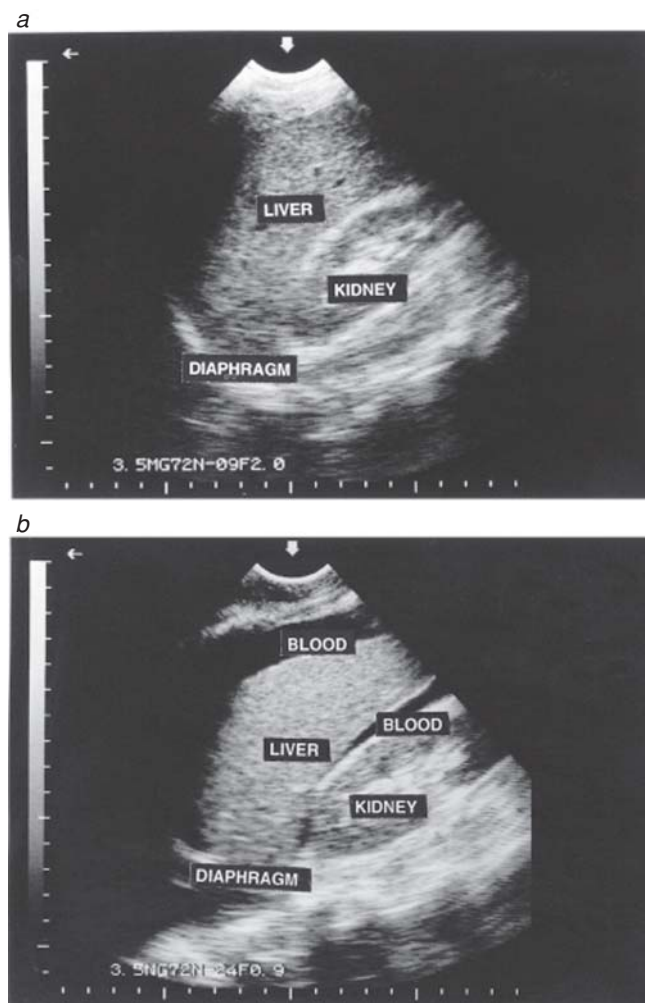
(a) A sagittal ultrasound image of liver, kidney, and diaphragm yields normal findings. (b) A sagittal ultrasound image of the right upper quadrant shows blood between the liver and kidney and between the liver and diaphragm.
